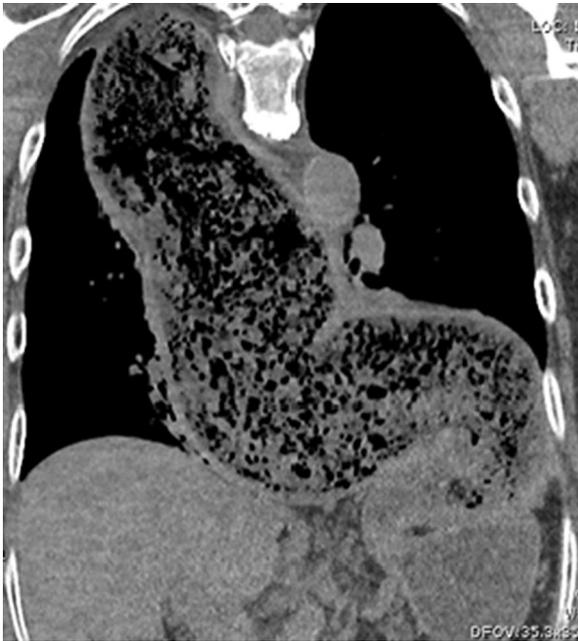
A coronal reformatted unenhanced CT image of the chest in the same patient, as shown in Fig. 2, clearly delineates the contour of the dilated, tortuous, esophagus with its “sigmoid” appearance. The body of the esophagus is filled with debris, sags inferiorly, and abuts the each hemidiaphragm
